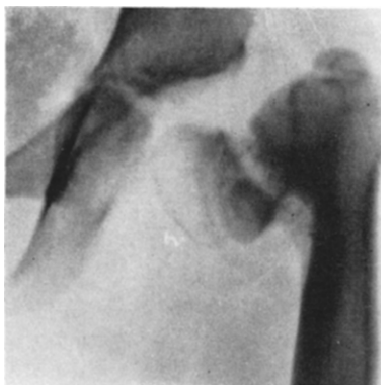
Case xviii. Roentgenogram January 5, 1932; marked coxa vara; broad defect across neck.
